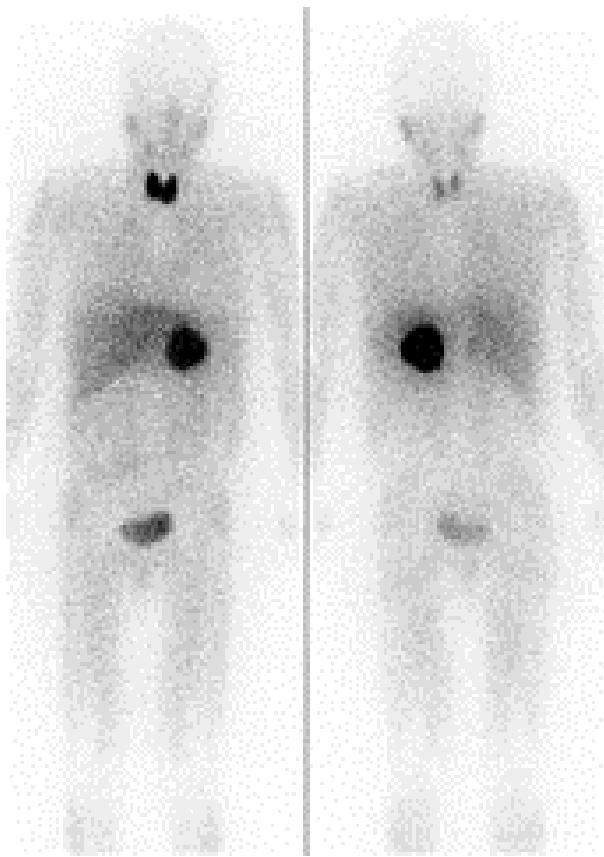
^{131}I -MIBG scintigraphy shows right adrenal pheochromocytoma as a dark round lesion in the center of the body.
